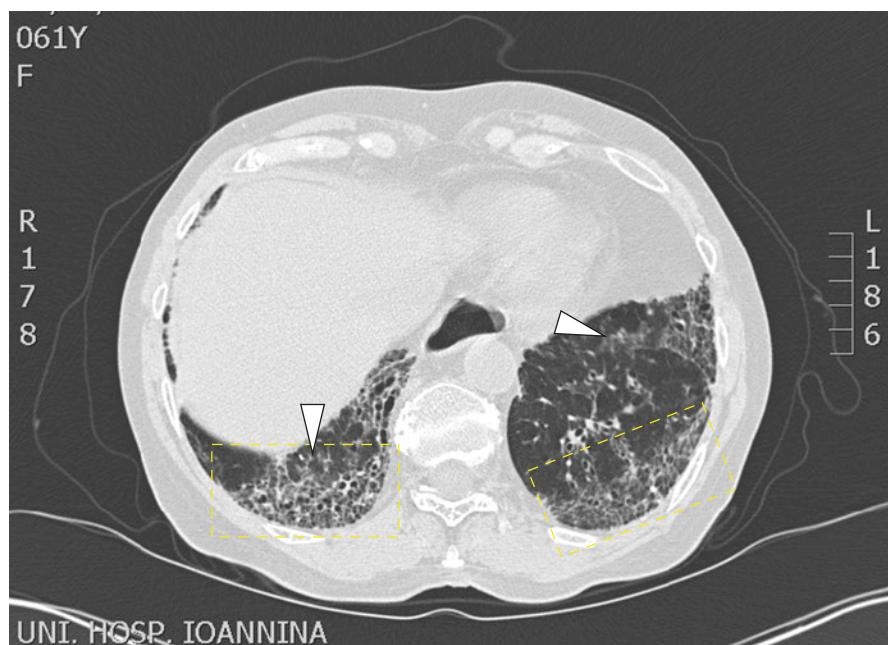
Lung involvement – High resolution computed tomography
